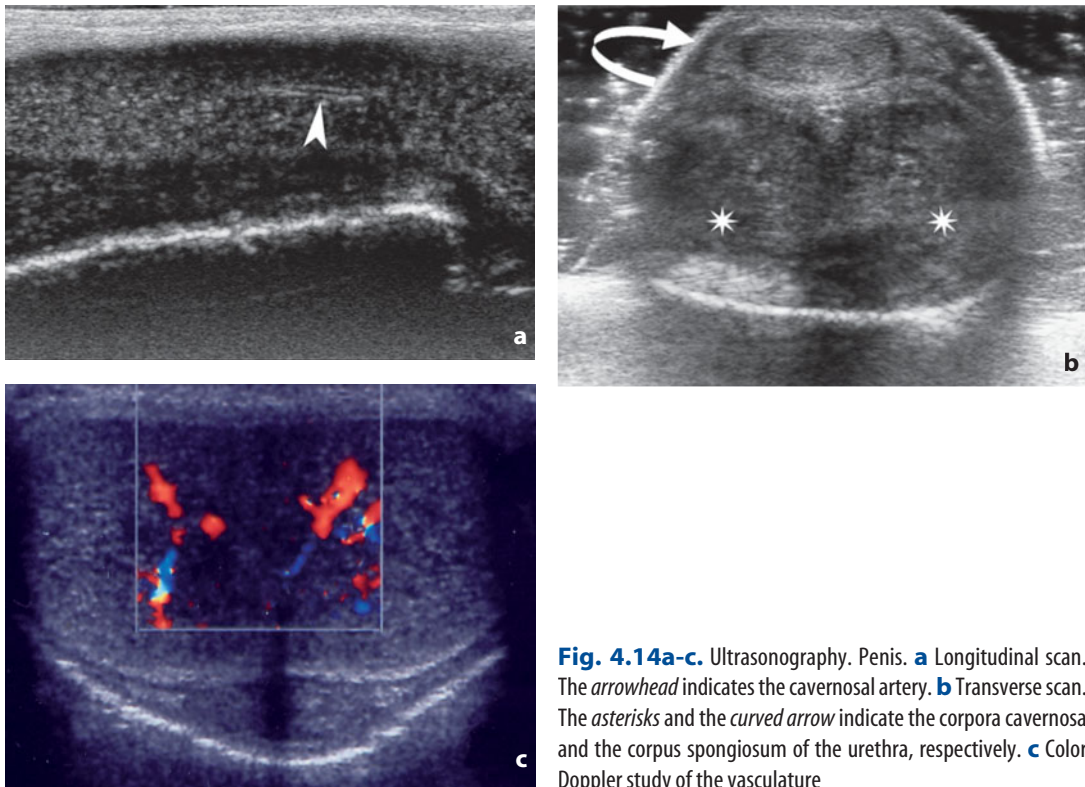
Ultrasonography. Penis. a Longitudinal scan. The arrowhead indicates the cavernosal artery. b Transverse scan. The asterisks and the curved arrow indicate the corpora cavernosa and the corpus spongiosum of the urethra, respectively. c Color Doppler study of the vasculature
